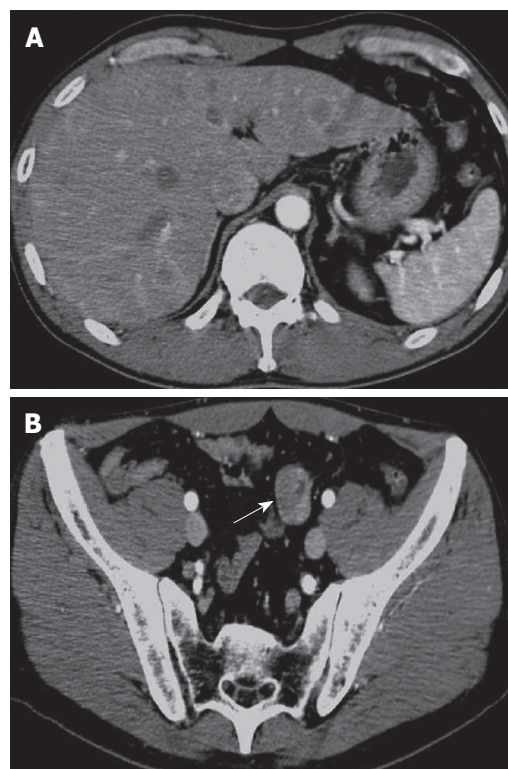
CT findings. A: Abdominal CT showed the multiple hepatic tumors with ring enhancement; B: Wall thickening of a part of the small bowel (arrow).
